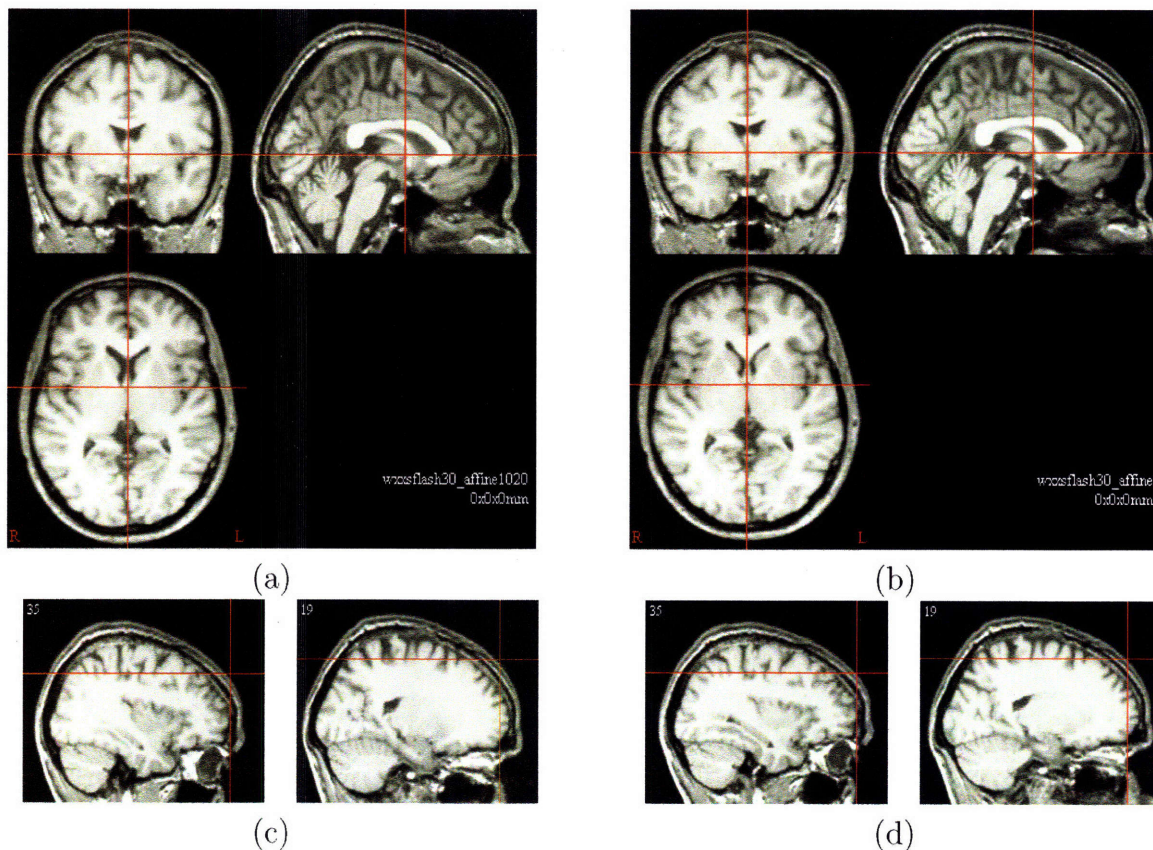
(a) Three slices, coronal, sagittal and axial (or transversal), of a subject's MRI volume registered to the MNI atlas using SLR_{10-20} ; (b) corresponding three slices from (a) but here SPM5 is used to register the subject's head to the atlas'. The intersection of the red crossbars indicates the location of the Anterior Commissure (AC) point on the two registered volumes. (c) Two other sagittal slices ($x = 35$ and $x = 19$) for the SLR_{10-20} and (d) for the SPM5 registration algorithm. The red crossbars intersection points in these figures highlight the differences between the two registration algorithms: in the SPM5 registered head, the red lines junctions fall on top of the scalp, whereas in the SLR_{10-20} registered head the crossbars intersections fall few millimeters outside the scalp, suggesting that the volumetric-based registration results in a slightly larger head size than the SLR_{10-20} registration.
